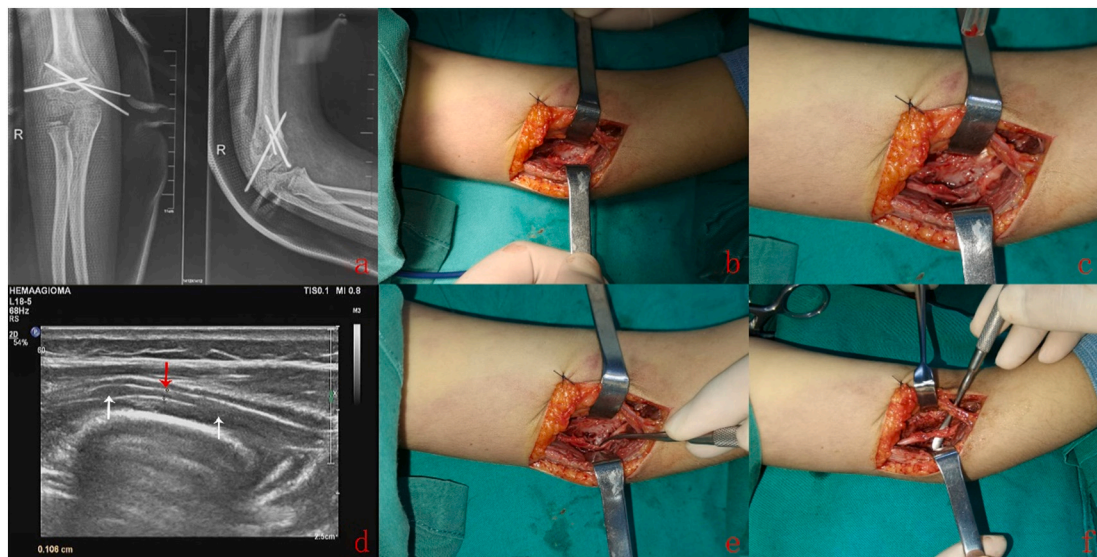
a, The postoperative radiographs 24 days after the initial surgery showed the fracture was well reduced and in union. b, showed the trapped radial nerve intraoperative exploration. c showed the radial nerve after partial release. d, showed the narrowed part of the trapped radial nerve (red arrow) in ultrasound. e and f, showed continuity of the restored nerve after release.
